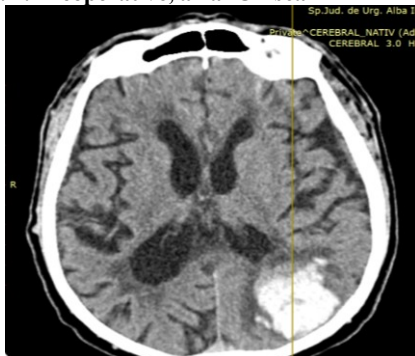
Preoperative, axial CT scan
